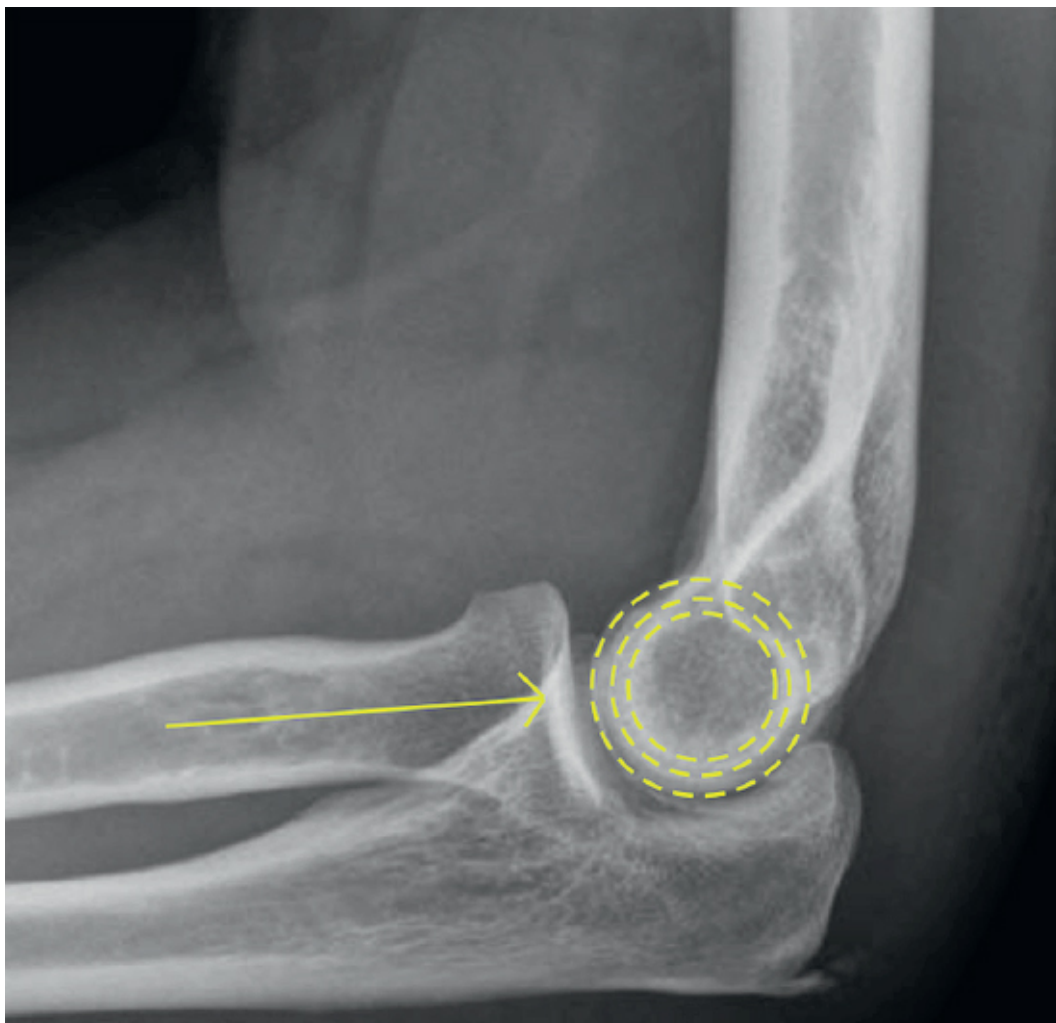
A normal lateral elbow x-ray with the three concentric *circles* represented with *dashes* and a *line* drawn along the radial neck pointing to the center of the capitellum indicating a concentric radiocapitellar reduction.
